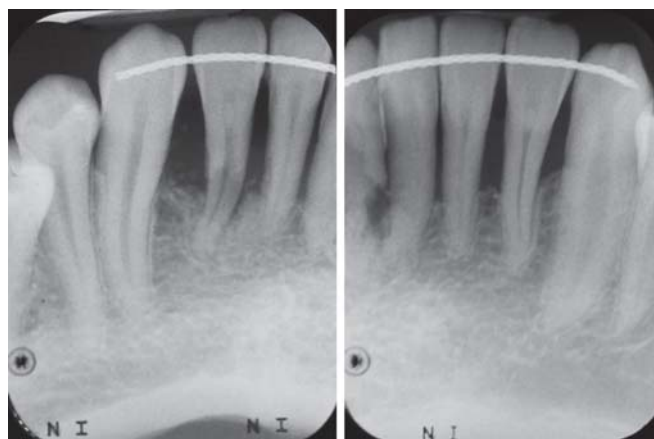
Periapical X-ray of lower anterior teeth as patient returns to NYUCD after 2.5 to 3 years lapse in care (2012)
